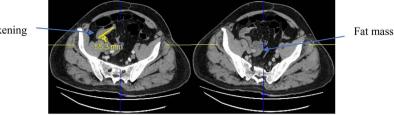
CT-Scanner showed a fat mass and ileal thickening evoking a lipoma ileal.
